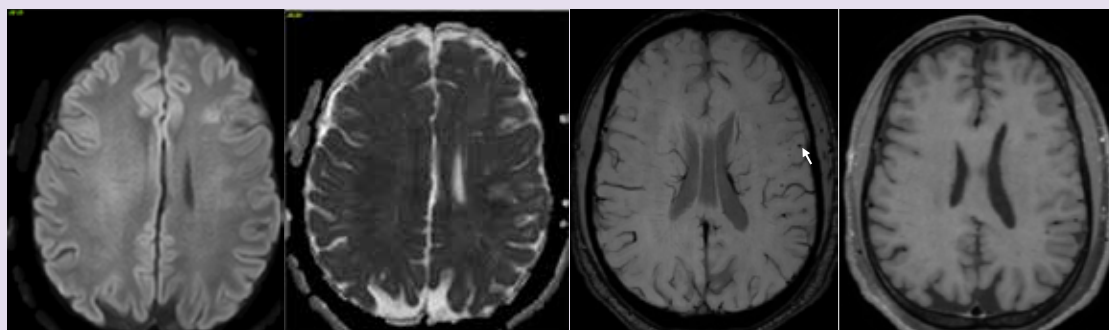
DWI images (a) show diffusion-bright signal without corresponding restriction on ADC maps, consistent with T2 shine-through. SWI images demonstrate punctate blooming foci in the left frontal lobe, raising the possibility of calcific foci. Post-contrast images (c) show no appreciable enhancement within the brain parenchyma.
